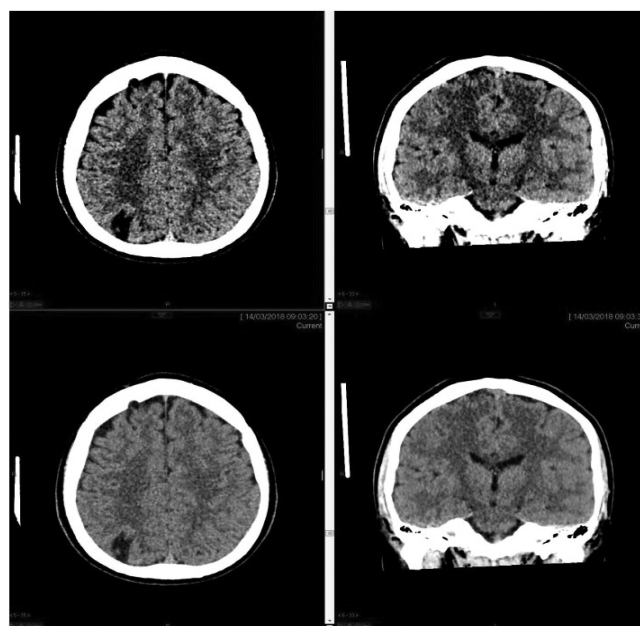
Brain computed tomography demonstrating loss of gray-white matter differentiation in the right high parietal lobe due to focal edema
